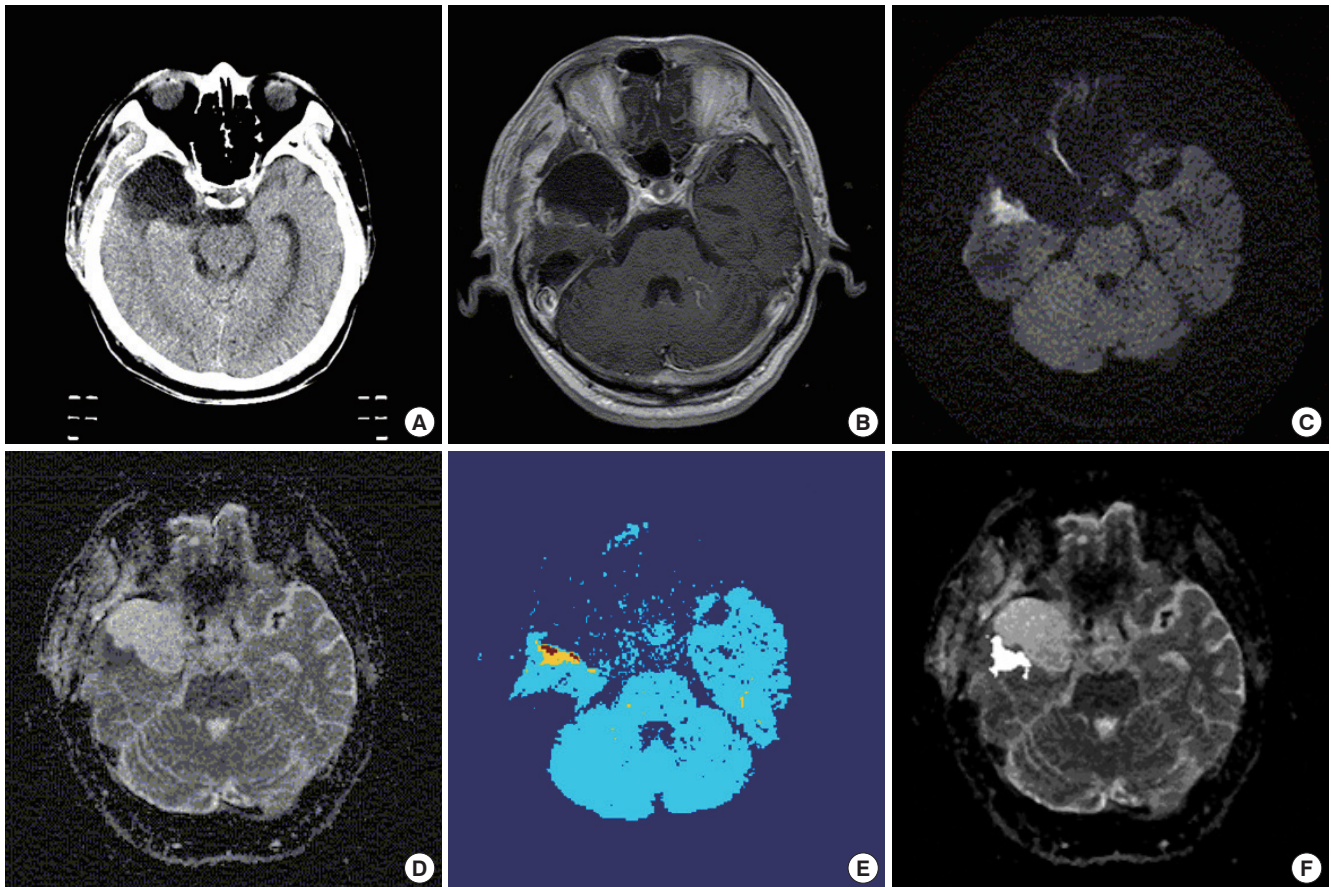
Multi-modal and post-processed images used to determine the high-risk tumor volume in a high-grade glioma. (A) Computed tomography image. (B) Contrast enhanced-T1 weighted image. (C) Diffusion-weighted (DW) image ($b=1,000$ s/mm²). (D) ADC map. (E) DW ratio map with normalized average diffusion values of the contralateral normal brain tissues. The red and orange regions represent double- and triple-restricted water diffusion, respectively. (F) Extracted malignant residual tumor volumes on ADC maps with quantitative analysis for suspicious high-risk lesions.
